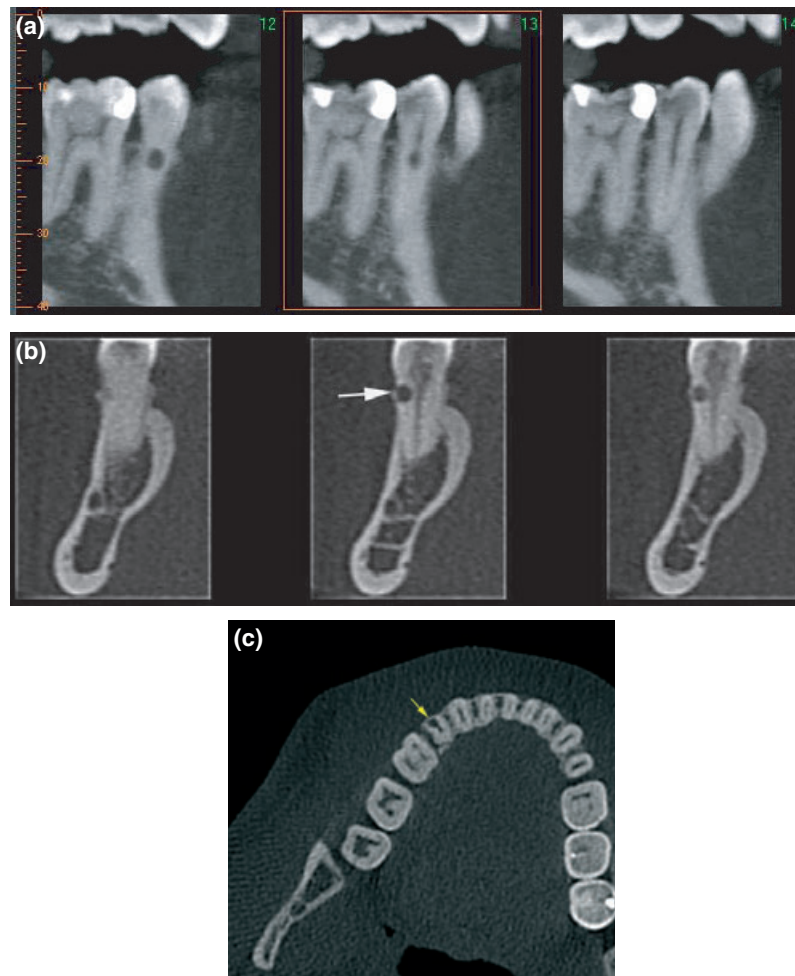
Cone beam computed tomography scans. (a) top left, sagittal slices; (b) top right, coronal slices – the resorptive lesion has not perforated into the root canal; (c) lower left, axial slice. Note the thin layer of cortical bone overlaying the resorptive lesion (yellow arrows).
